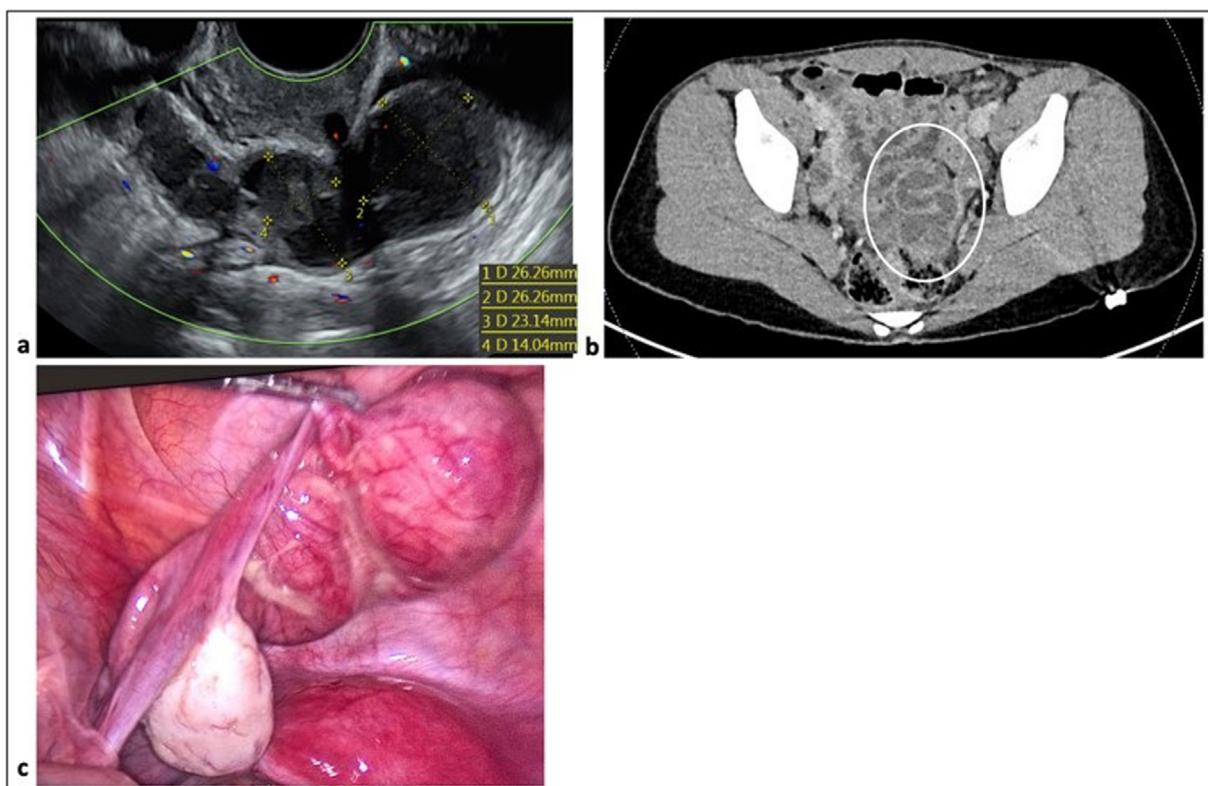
Pyosalpinx, late complication of conservative treatment of isolated torsion of fallopian tube. Transvaginal ultrasound (a) and CT scan (b) findings, with corresponding laparoscopic appearance (c).
